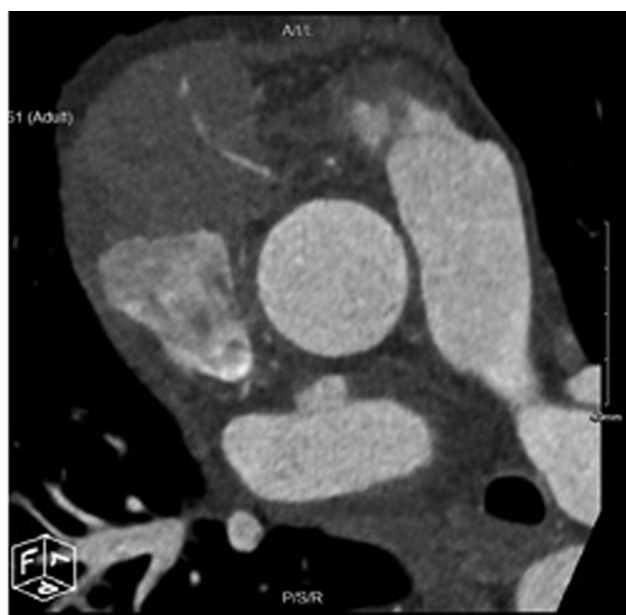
Computed tomography coronary angiography with right coronary encased by tumor.
